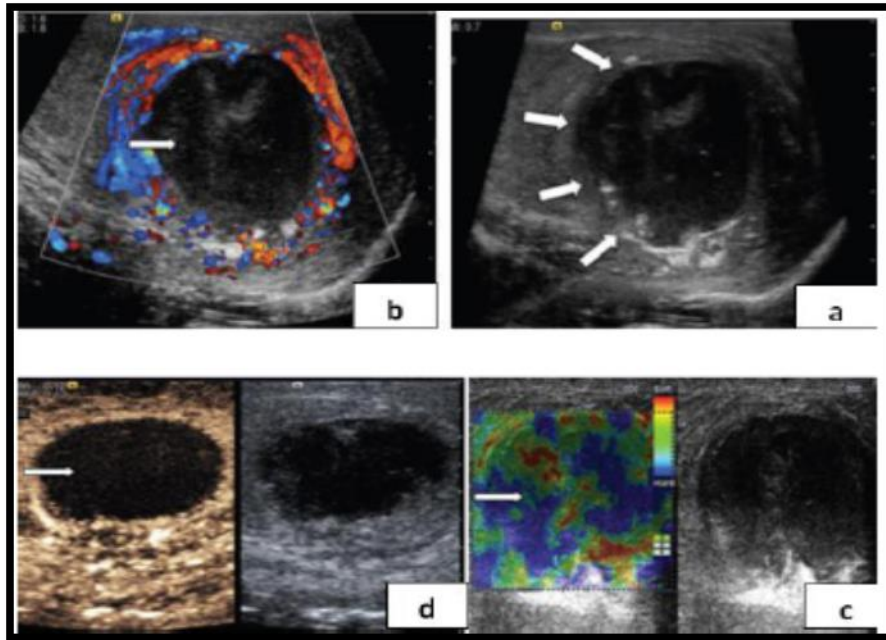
shows the testicular abscess (a) On B-mode ultrasound a focal lesion with low internal echoes (arrows) is seen in a patient with history of resolving epididymo-orchitis. (b) On color Doppler ultrasound there is increased vascularity at the periphery of the lesion but none within the lesion (arrow). (c) Contrast-enhanced ultrasound image demonstrating increased absence of vascularity in the abscess (arrow) with some rim enhancement. (d) Tissue elastography demonstrates a heterogeneous pattern of firmness but no focal “hard” lesion is demonstrated (arrow) (Stewart and Sidhu 2007).
